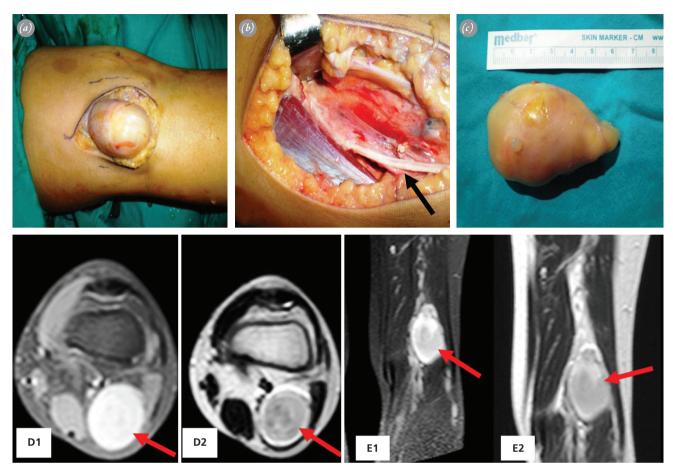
(a, b) Intraoperative view of case 7; (b) the common peroneal nerve is shown by the arrow; (c) postoperative view of the tumour; MRI showing axial T1-weighted (D1) and T2-weighted (D2) views with the lesion marked via the arrow; sagittal T1-weighted (E1) and T2-weighted (E2) views, with the lesion marked via the arrow. [Color figures can be viewed in the online issue, which is available at www. aott.org.tr]
